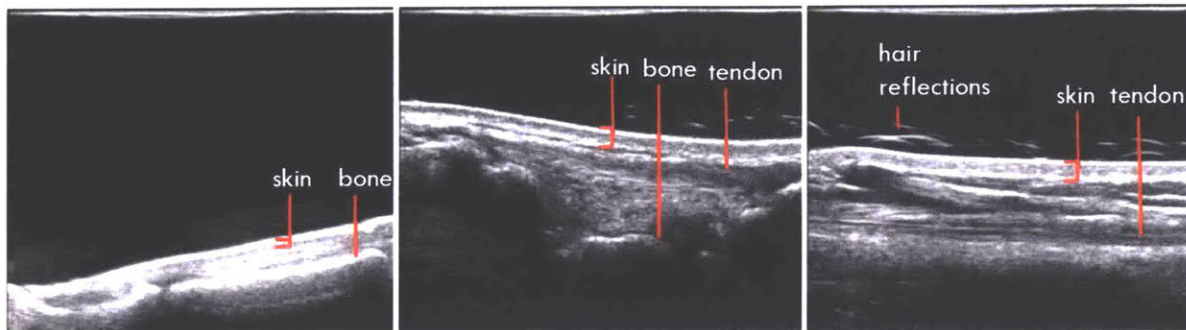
12 MHz ultrasound images showing the skin boundaries seen in the fingers (a), hands (b), and forearm (c)
